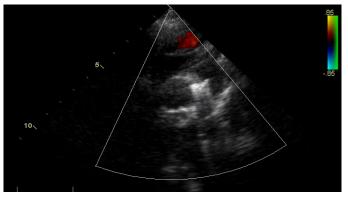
Echocardiographic control 24 hours after the procedure.
